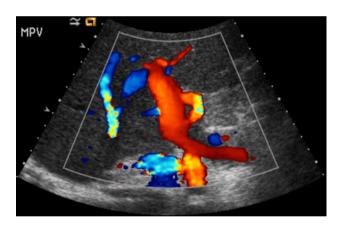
Wide patency of the portomesenteric system by color Doppler obtained 16 days after intervention
